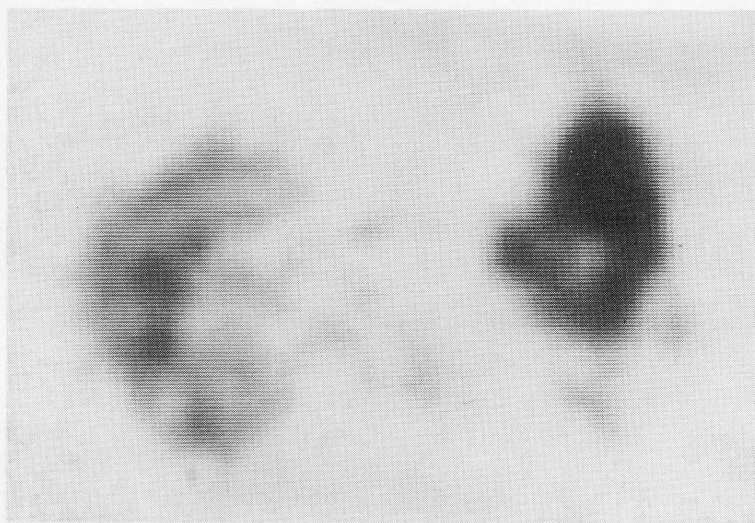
SPECT transaxial image suggests Ga-67 accumulates in the stomach.
